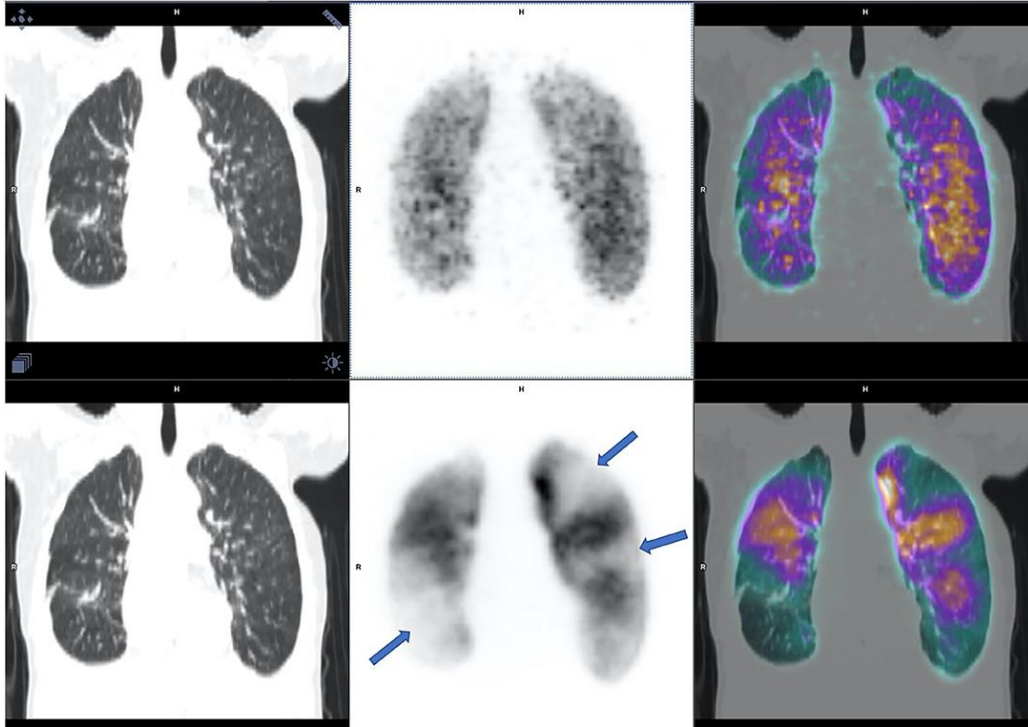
SPECT/TC-V/Q en un paciente con TEP. Le Pennec, Romain et al. (16)
